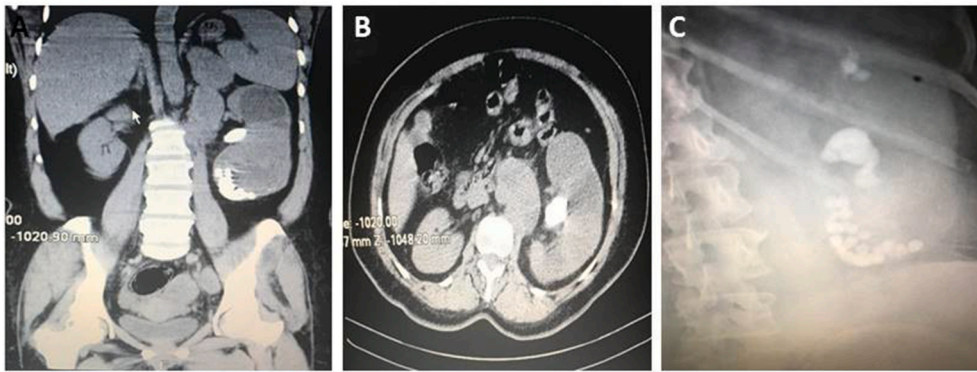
A- Non-contrast abdominal CT scan coronal image, severely enlarged left kidney with several varying size stones and para-aortic lymph nodes; B- Axial abdominal CT scan without contrast, left kidney enlargement with a large stone and an apparent para-aortic lymph node; C- Abdominal X-ray image, left kidney enlargement along with innumerable varying size stones.
